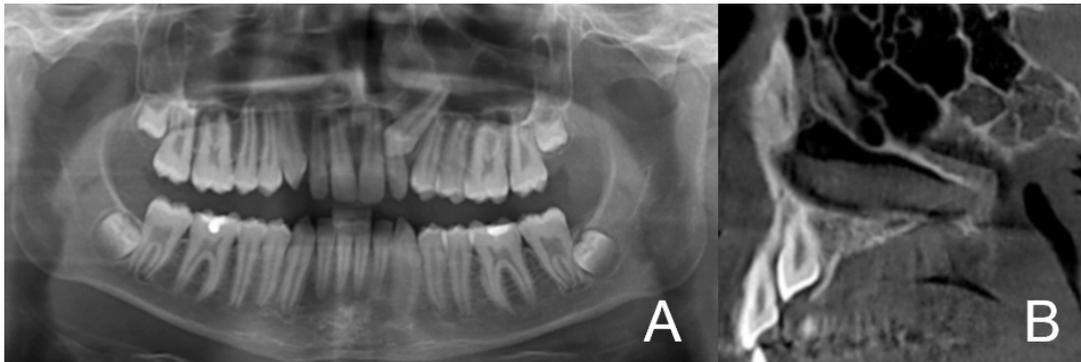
Absence of root resorption on the adjacent PLI: (A) on DPR image and (B) on CBCT image in the sagittal plane.
